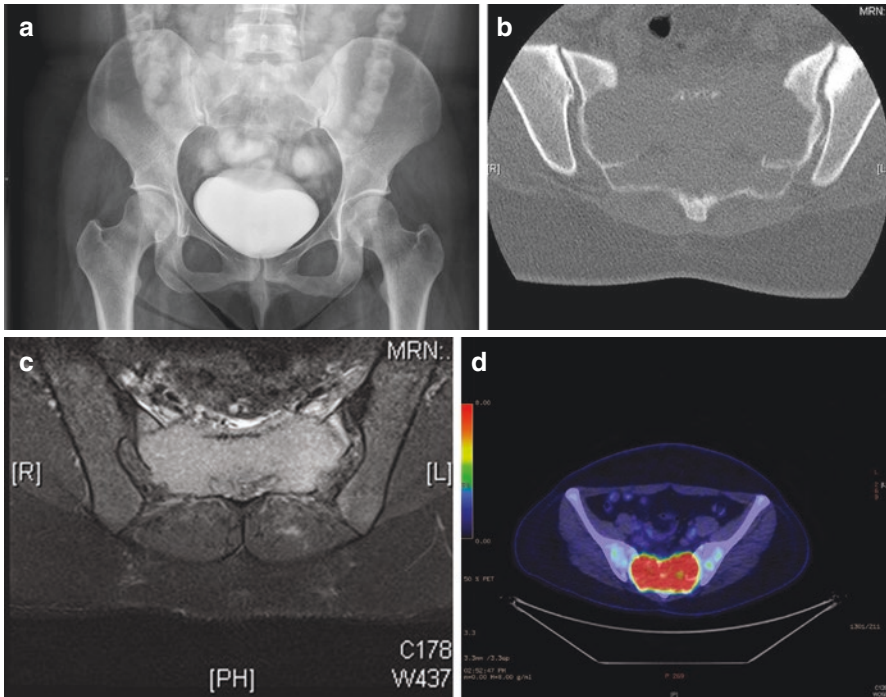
(a) A 31-year-old female presents with lower back pain and paraesthesia with plain X-ray showing loss of cortical definition of the left sacral foramina and lucency. (b) Axial bone targeted CT image shows large soft tissue mass involving the sacrum with bony destruction consistent with an aggressive process. (c) T2 fat-saturated MRI axial image confirming the soft tissue mass without crossing the sacroiliac joints. (d) Corresponding F18-FDG fused axial image showing marked tracer uptake. Subsequent percutaneous CT-guided biopsy demonstrated giant cell tumour of the bone
